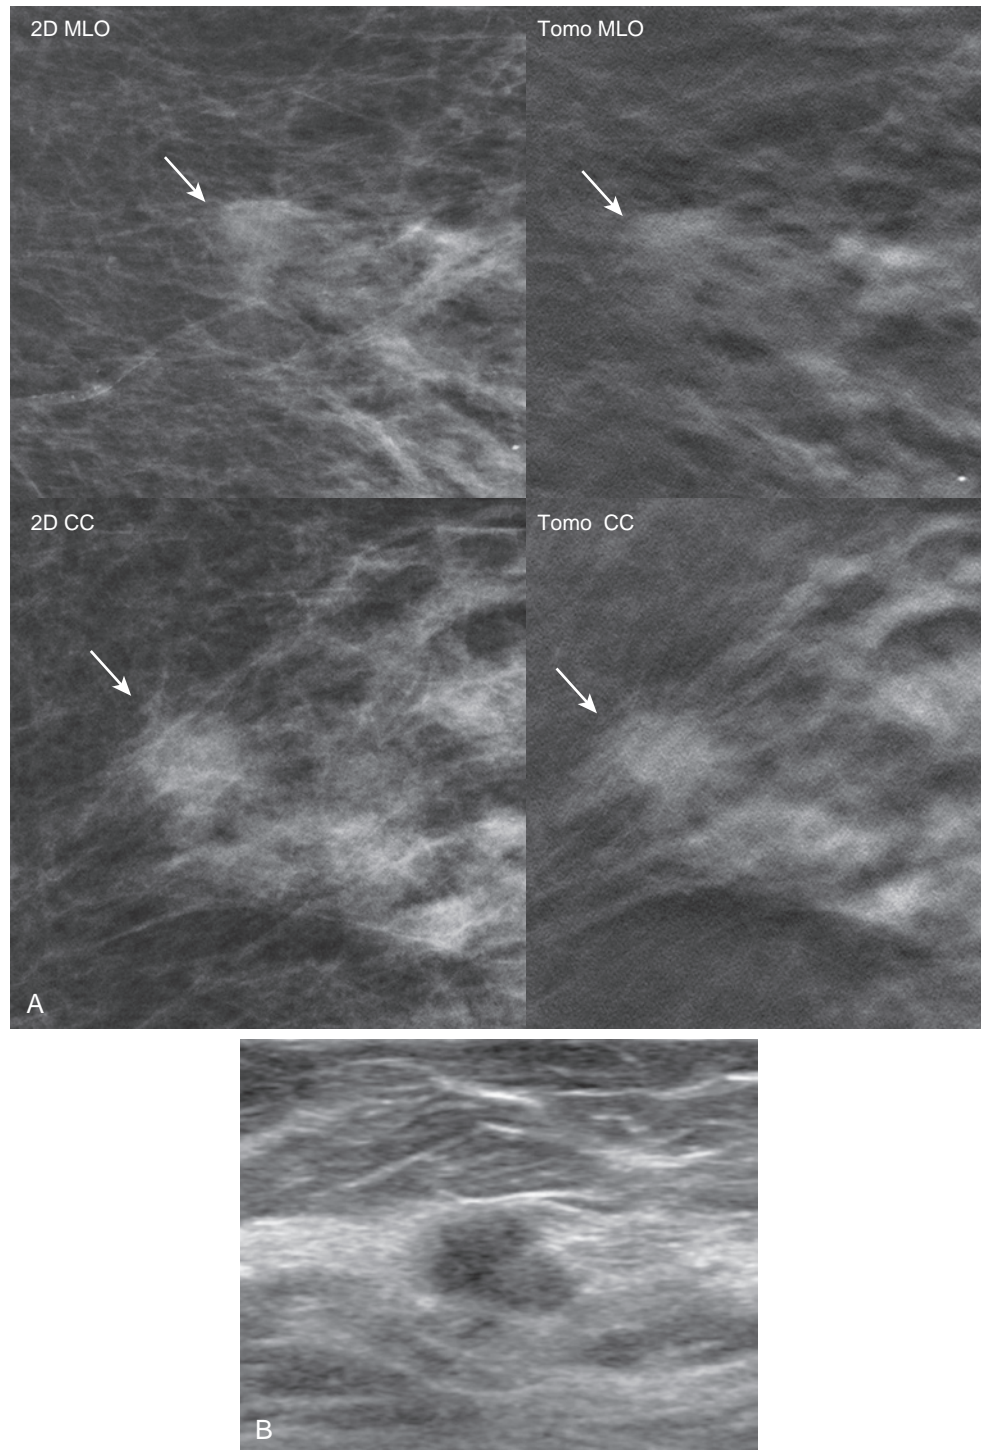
Focal asymmetry with suspicious features revealed on tomosynthesis (A) On a screening mammogram in an 69-year-old woman, a round spiculated mass (*arrows*) resembles fibroglandular tissue on the standard two-dimensional view but is better seen on tomosynthesis, particularly on the craniocaudal view. Additional spot compression views were not necessary. (B) Targeted ultrasound demonstrates a corresponding oval hypoechoic mass with indistinct margins. Ultrasound-guided core needle biopsy and surgical excision showed invasive ductal carcinoma, grade 2, ER/PR+, Her-, 0/2 SLN.
